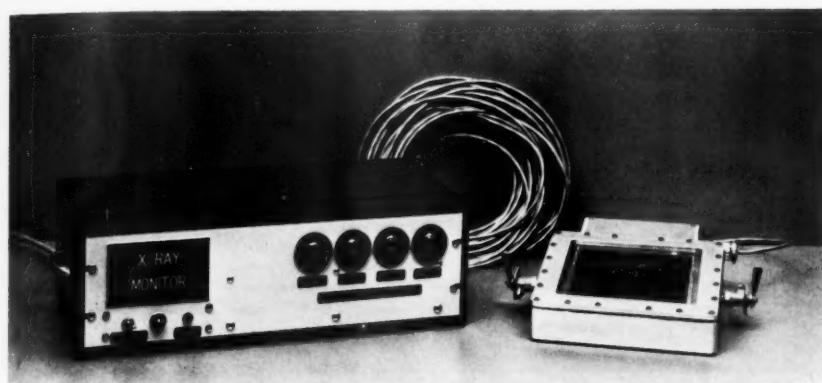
X-ray monitor, which measures total radiant energy projected on patients during radiographic and fluoroscopic exposures.
